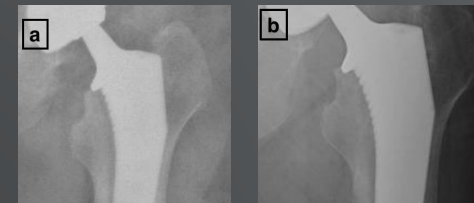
(a) Primary dual-taper THA patient without collar-calcus contact shown on intraoperative x-ray vs (b) 3 mm stem subsidence shown on an 8-week postoperative radiograph. Measurable subsidence occurred in 8.6% of patients implanted with dual-taper femoral stems.
